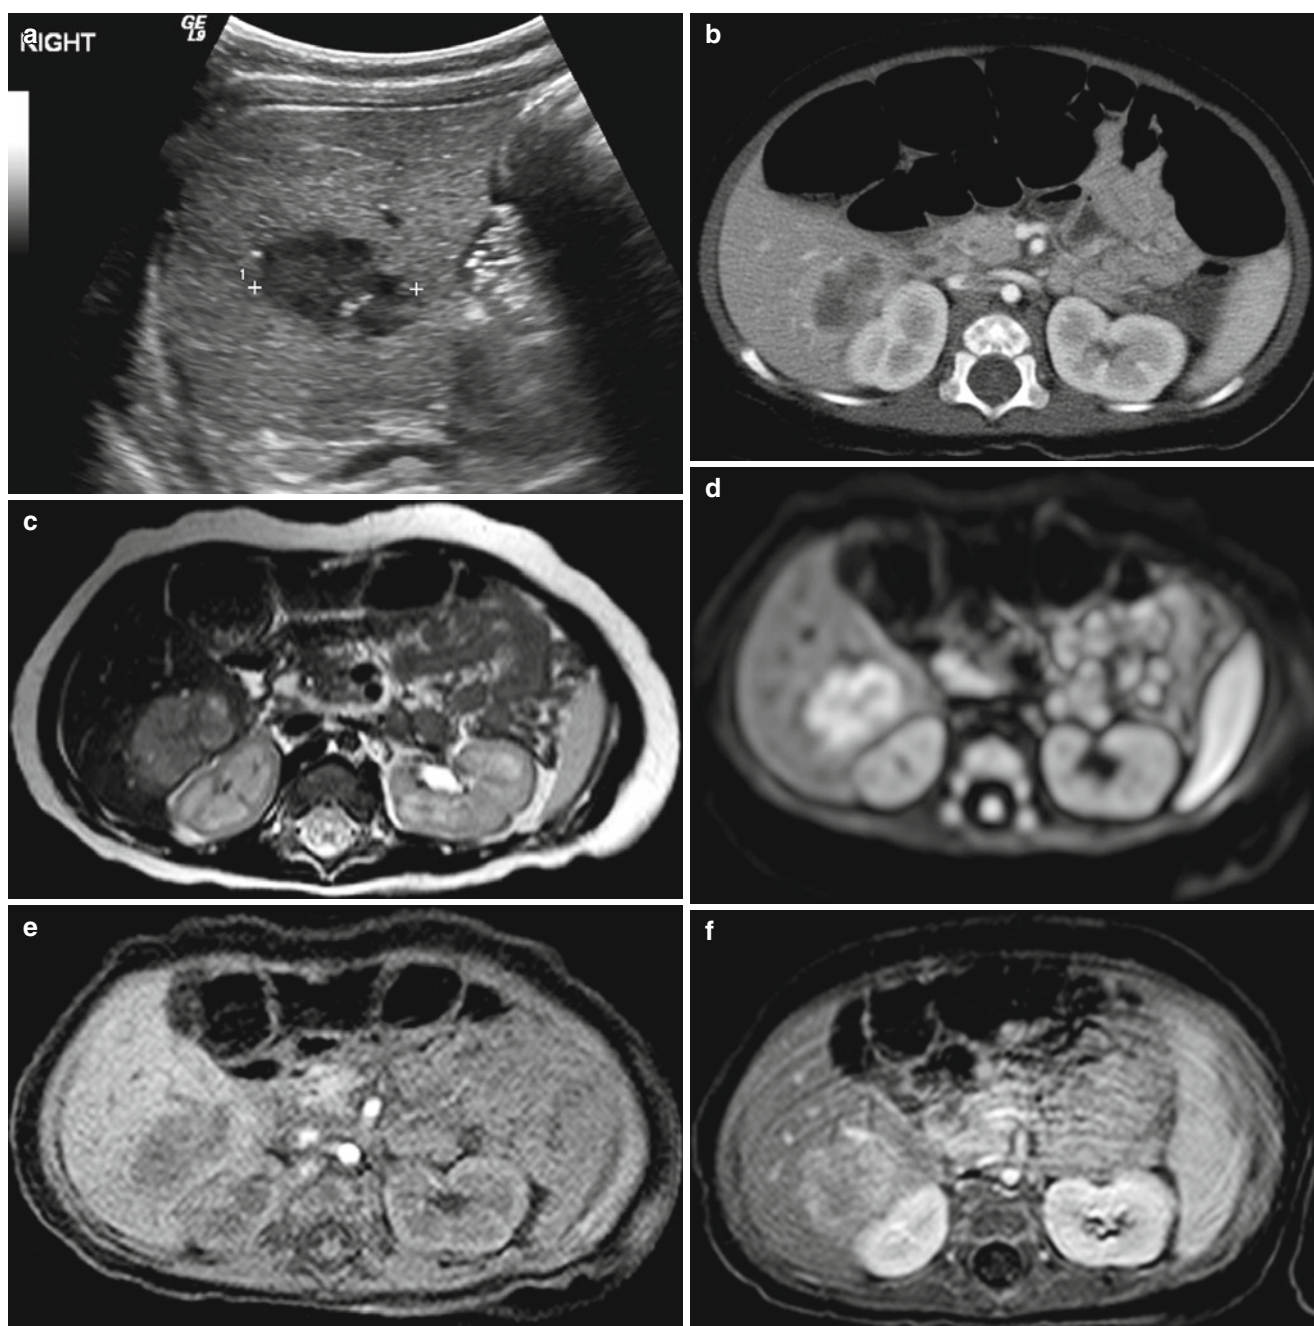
Hepatoblastoma in a 4-month-old boy. (a) Abdomen US shows multilobulated hypoechoic mass with internal hyperechoic portion in right lobe of liver. (b) Contrast-enhanced abdominal CT shows low-density hepatic mass with peripheral enhancement. (c) T2-weighted MR image shows multilobulated mass with intermediate to high signal
